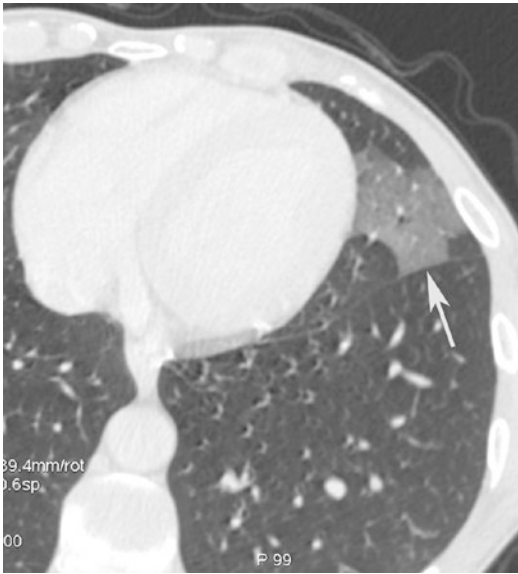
Ground-glass opacity. CT axial scan evidences a lingular ground-glass opacity (*arrow*) with preservation of bronchial and vascular markings
